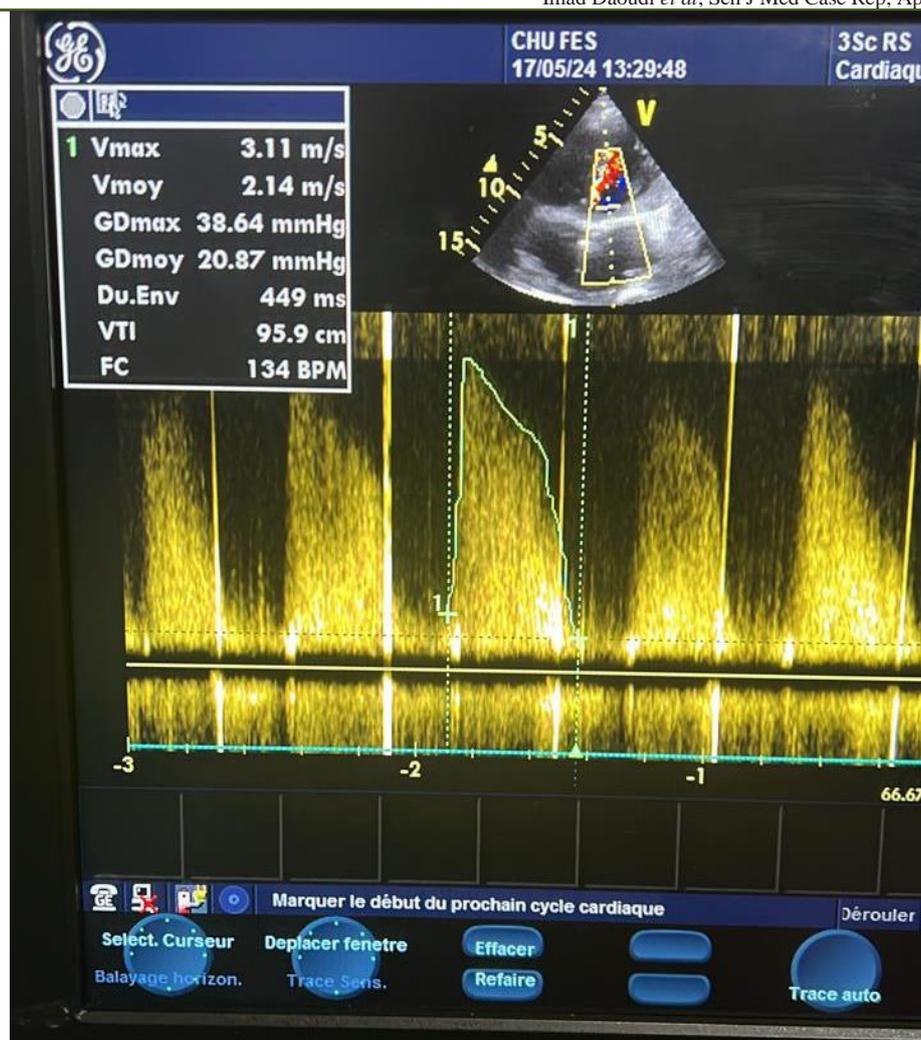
Transthoracic Echocardiography on Postoperative Day 4
